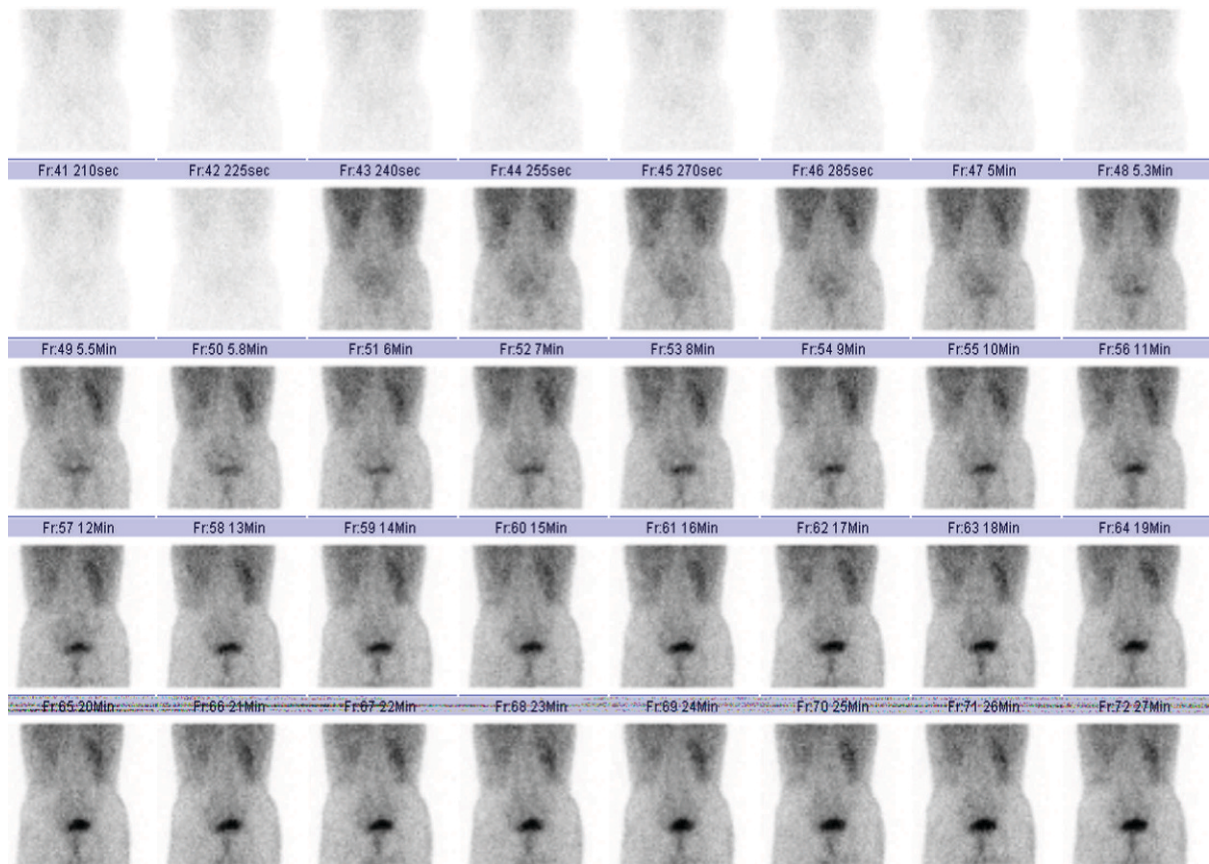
A Tc99m DTPA perfusion scintigraphy revealed a delay in the initiation of perfusion and deterioration of function for both kidneys, affecting left kidney particularly.
